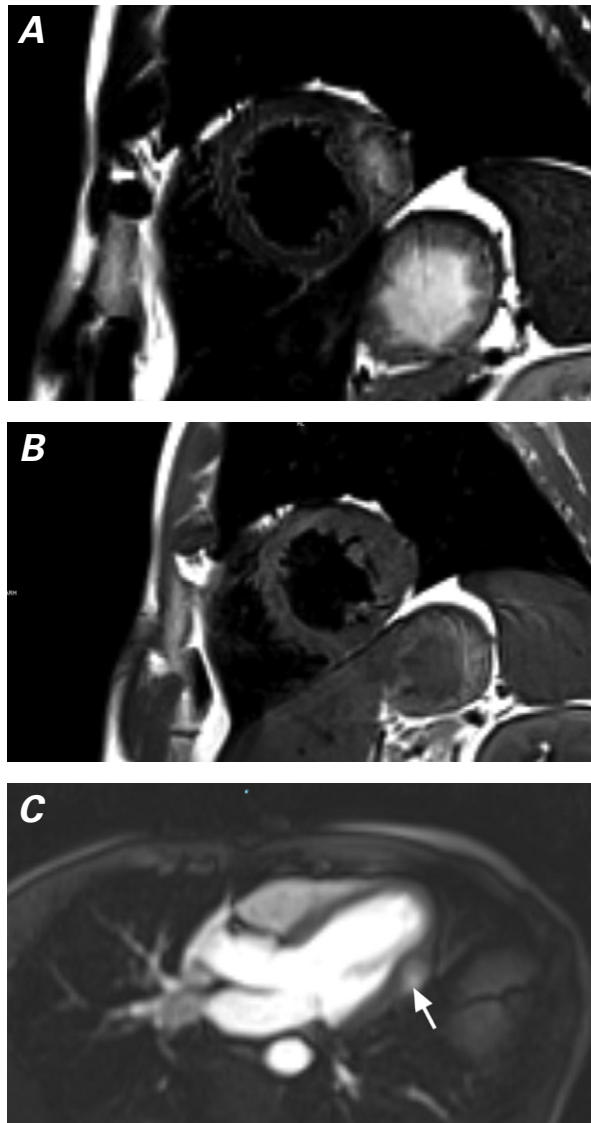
Cardiac magnetic resonance images. A) The T2-weighted fast-spin echo sequence shows that the tumor has higher signal intensity than does the myocardium. B) The T1-weighted fast-spin echo sequence shows an isointense signal in comparison with the surrounding myocardium. C) During the first-pass infusion of gadolinium contrast medium, the tumor (arrow) enhances rapidly.
